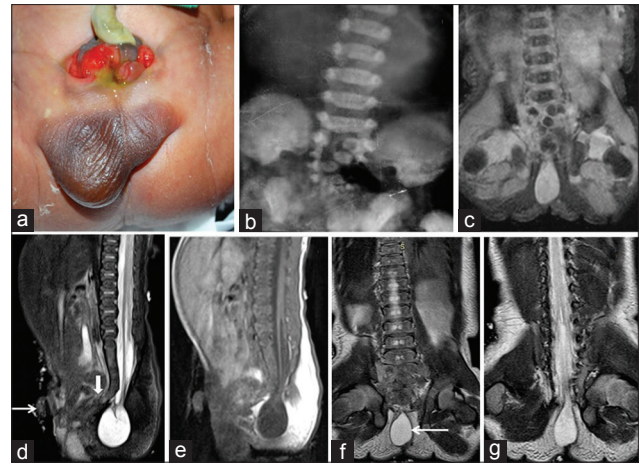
A 3-day-old male infant, (a) photograph of the patient shows omphalocele and bladder exstrophy. (b) X-ray anteroposterior view of the lumbosacral spine and (c) coronal gradient-recalled echo images show segmentation defects in the sacrum. (d) Sagittal short-tau inversion recovery, (e) T1-weighted image, (f and g) coronal T2-weighted images show T1 hypo- and T2 hyper-intense terminal myelocystocele (← arrow) with tethered cord and anterior abdominal wall defects and herniation of bowel loops (→ arrow). Reversed sacral curvature is noted with agenesis of coccygeal segments (↓ block arrow) representing omphalocele, cloacal exstrophy, imperforate anus, and spinal complex with Type V caudal regression syndrome.
